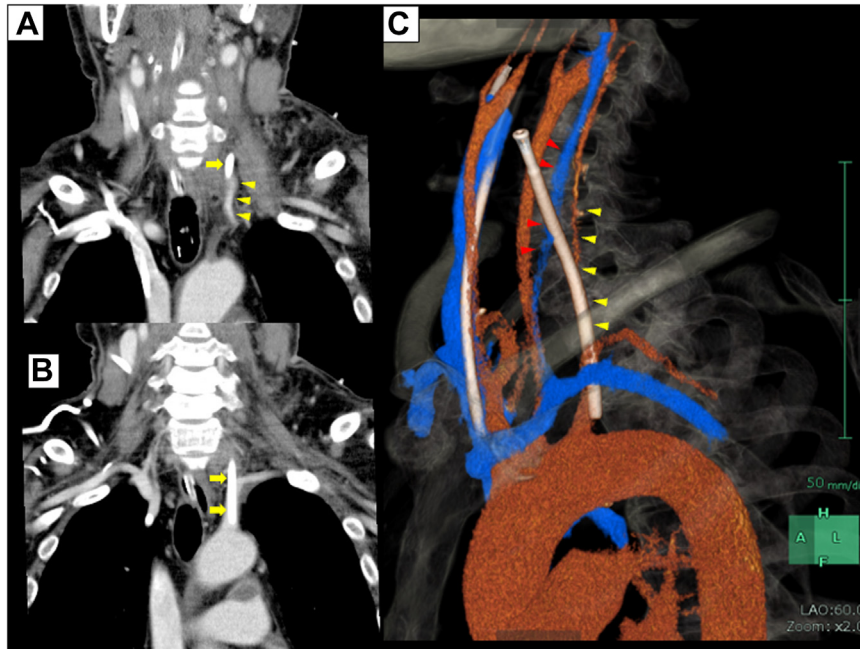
Contrast-enhanced computed tomography (CT) scan showing an 8F sheath (yellow arrows) inserted into the left vertebral artery (yellow arrowheads) through the jugular vein (red arrowheads), with the tip of the sheath reaching the left subclavian artery (SCA). A and B, Arterial phase coronal views. C, Three-dimensional reconstructed view.
